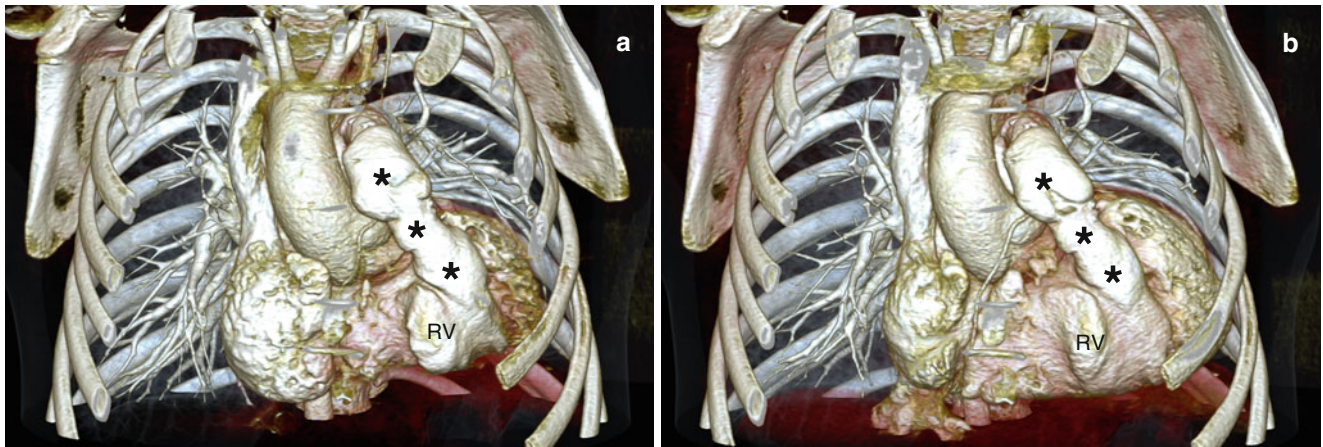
Rastelli operation for pulmonary atresia with ventricular septal defect. Anterior volume-rendered CT images obtained at the end systole (a) and the end diastole (b) show a patent right ventricle (RV) to pulmonary artery conduit (*asterisks*) and good ventricular contraction
